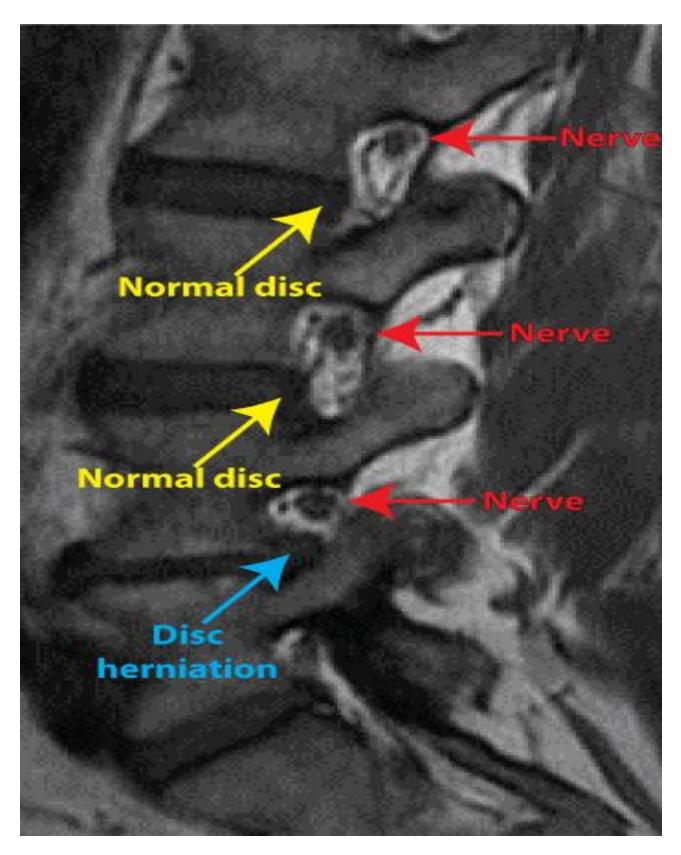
MRI showing pinched nerve with disc herniation
